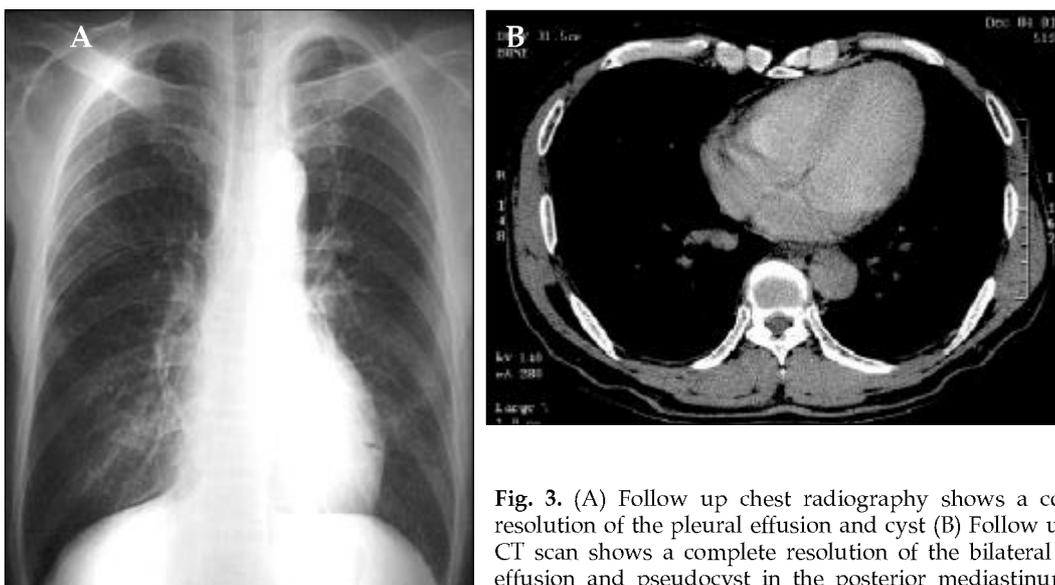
(A) Follow up chest radiography shows a complete resolution of the pleural effusion and cyst (B) Follow up chest CT scan shows a complete resolution of the bilateral pleural effusion and pseudocyst in the posterior mediastinum.
